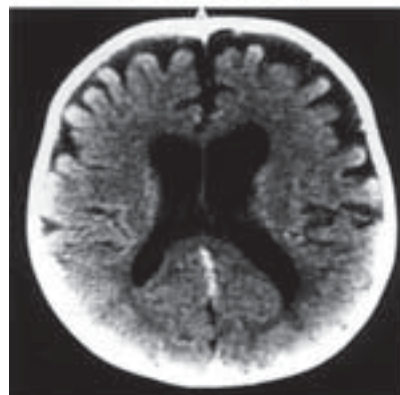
Imaging. A. Radiograph of lumbar spine of patient 1 at 7 years of age revealing caudal narrowing of the spinal canal and a shadow of a ventriculoperitoneal shunt. B. CT scan of the brain of patient 3 at 11 months old revealing hydrocephalus.
